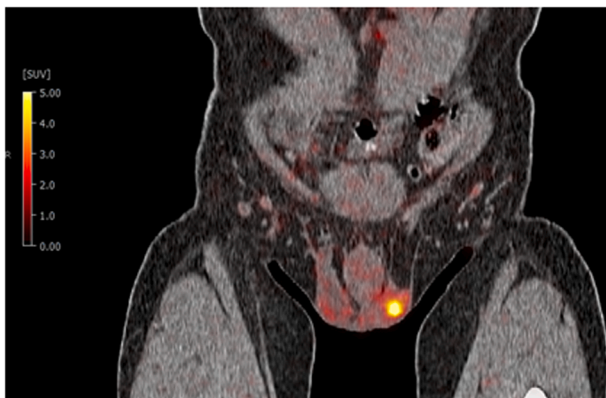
Scrotal tracer enhancement in the PSMA PET/CT.
